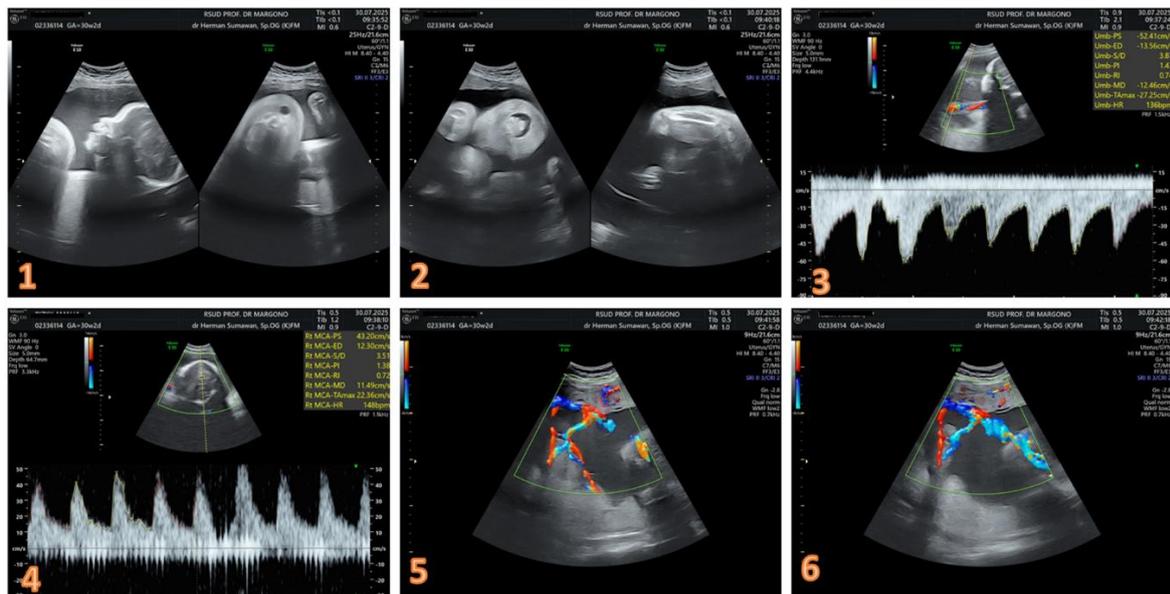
Ultrasonography at 30 weeks of pregnancy
